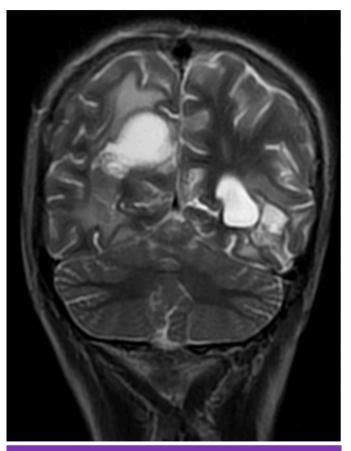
Postoperative brain MRI showed an increase in intensity consistent with edema and around the postoperative cavities
